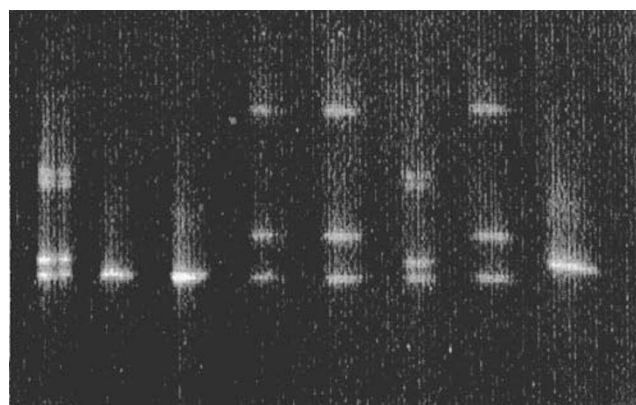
DGGE patterns of fragment A in the 6 members of the family who are all carriers of the *cd5(-CT)* mutation: Lane 1, III-3 (heterozygous); lanes 2 and 3, III-4 (homozygous); lanes 4, 5, 6 and 7, III-1, III-2, II-2 and II-1 respectively (all heterozygous, but note that lanes 4, 5 and 7 are anomalous because of the *cd2* polymorphism). In lane 8 the normal *w.t.* pattern without the *cd2* polymorphism
